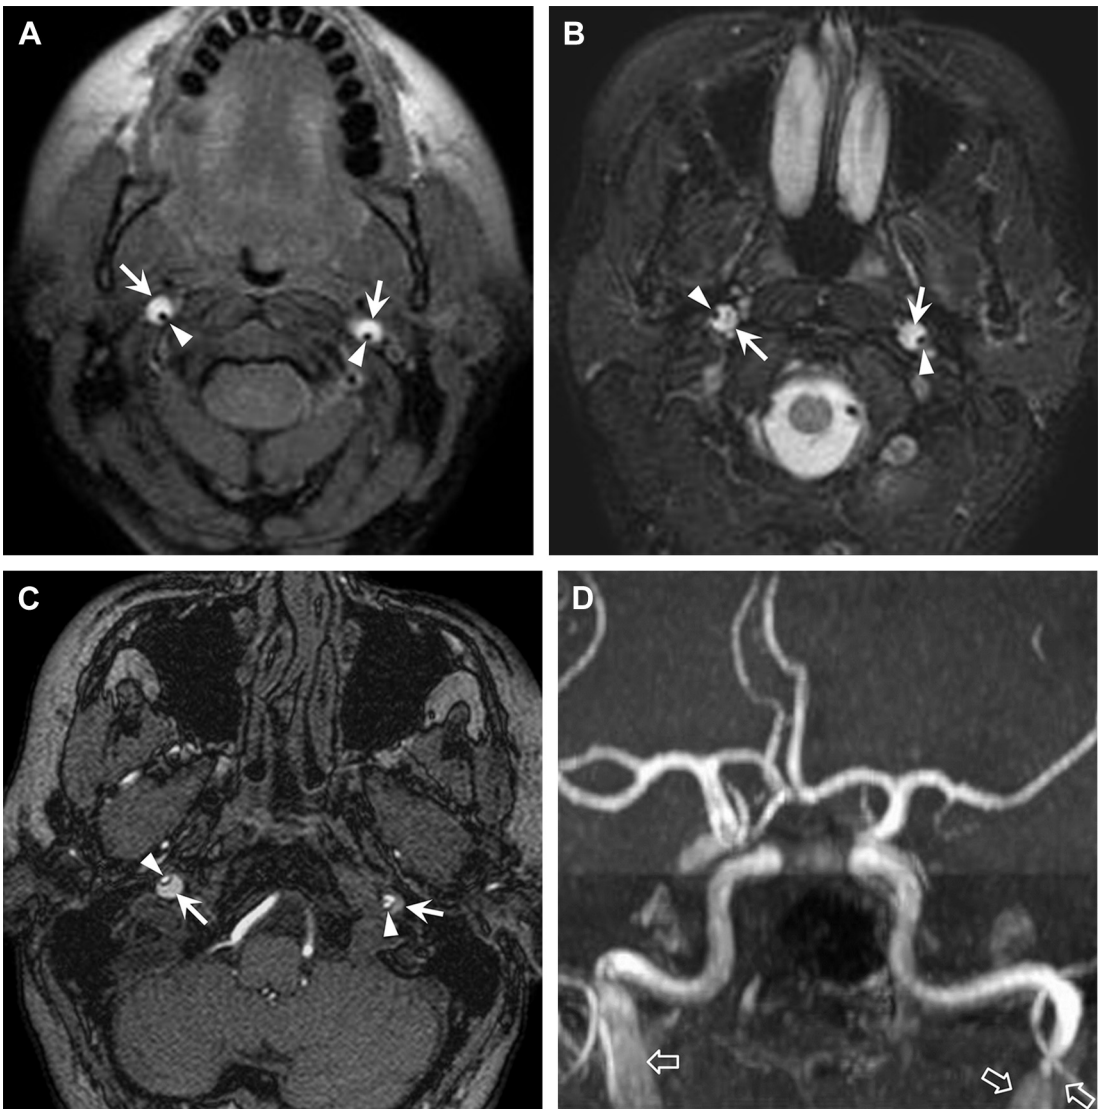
Bilateral ICA dissections causing severe luminal compromise. Axial proton density-weighted (PD-W) (A) and T2-weighted (B) MR images as well as source (C) and MIP (D) images from a 3D-TOF MRA demonstrate bilateral ICA dissections 1 week following neck trauma. Note that the true lumens (*arrowheads*) are severely narrowed by intramural hematoma (*arrows*). The intramural hematoma is hyperintense and very visible on the PD-W and T2-weighted images. The hematoma is also hyperintense on the T1-weighted source image, which can be mistaken for flow on the MIP image (*open arrows*).
